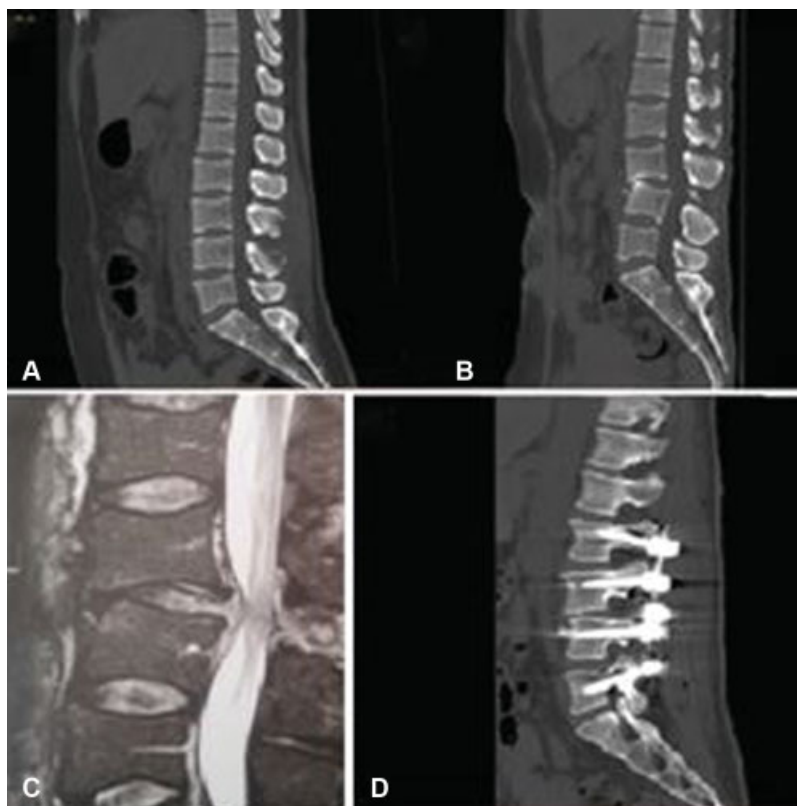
(A) Sagittal CT of the thoracolumbar spine without evident alterations related to trauma at admission. (B) CT of thoracolumbar spine performed ~ 4 months after the initial event, when the patient evolved with lumbar pain and deformity, showing listhesis of L3 over L4 with distancing of spinal processes. (C) MRI in a T2-weighted sequence showing listhesis of L3 over L4, posterior ligament injury, and cauda equina compression. (D) Postoperative control CT showing arthrodesis by the posterior pathway between L2 and L5.
